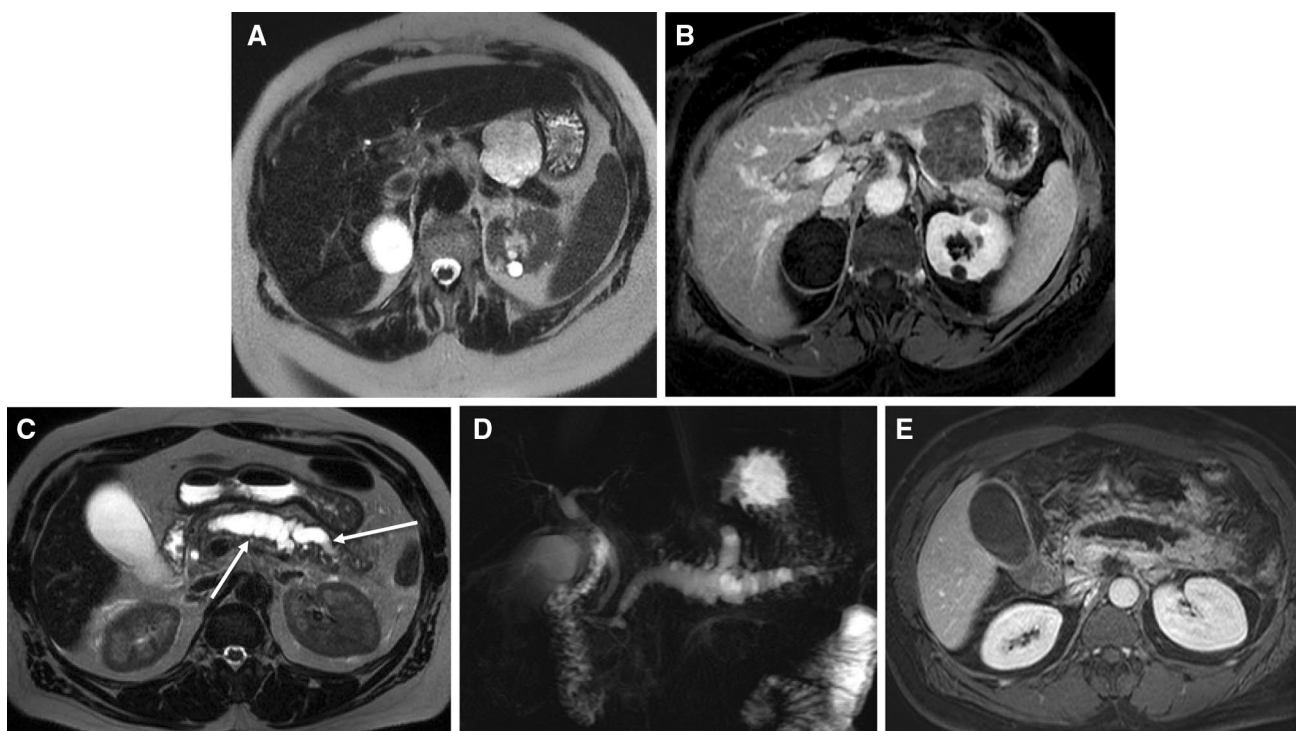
MRI of pancreatic cystic lesions. The axial T2-weighted (a) and T1-weighted fat-suppressed (b) images in a 75-year-old woman reveals a lobulated and septated cystic lesion corresponding to a serous cystadenoma—no ductal communication was established on the MRCP images (not included). The axial T2-weighted image in a different patient with a main duct intraductal papillary mucinous
